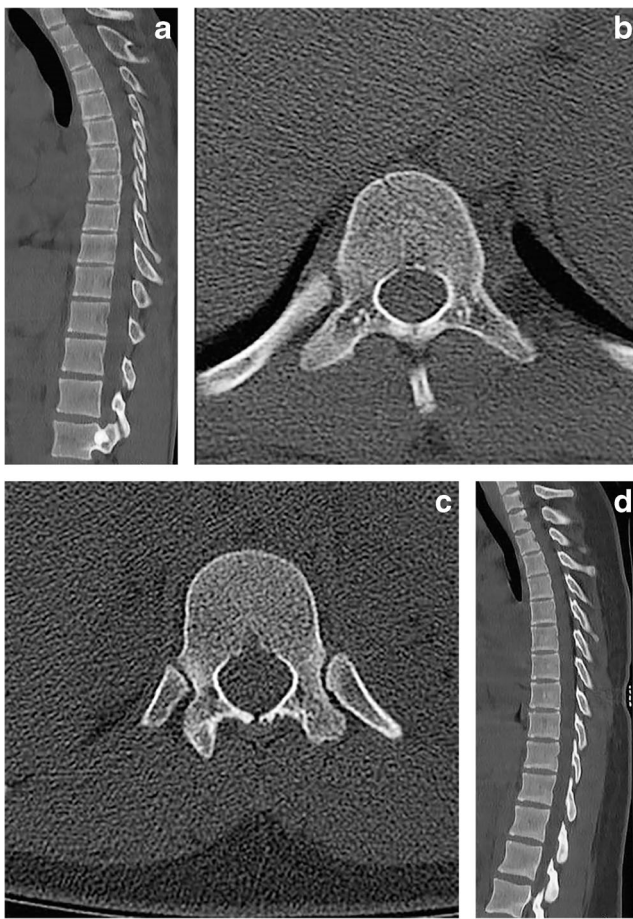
Image comparisons at different dose levels. a, b CT images at level T11 in a 15-year-old girl reformatted in sagittal (a) and axial (b) planes. Images were obtained with 130 kV, 113 mAs and a collimated slice width value of 1.2 mm. The scan length was 58.8 cm and the dose-length product (DLP) was 731.5 mGy·cm. The girl's body mass index (BMI) was 22.7 kg/m². c, d CT images of the T11 vertebra in a 16-year-old boy reformatted in the axial (c) and sagittal (d) planes. Images were obtained with 110 kV, 115 mAs and a collimated slice width value of 1.2 mm. The scan length was 57.4 cm and the DLP was 500.7 mGy·cm. The boy's BMI was 24.8 kg/m². In the second patient, DLP was lower than in the first patient, with preserved image quality, although the second patient's BMI was higher
